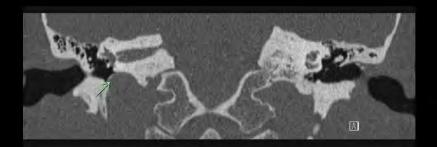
Coronal CT image showing a high-riding jugular bulb protruding into the floor of the middle ear cavity. The bony plate overlying the vestibular aqueduct is thinned, indicating potential vulnerability in this area. This anatomical variation can be clinically significant in terms of middle ear and inner ear structures.
